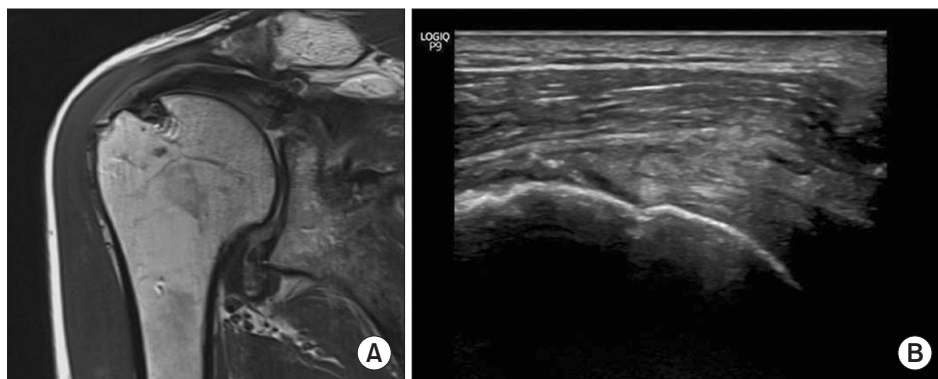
Follow-up magnetic resonance imaging (A, coronal view) and ultrasonography (B, longitudinal view) of the right shoulder of a 63-year-old men at 6 months after superior capsular reconstruction with an Achilles tendon allograft.
